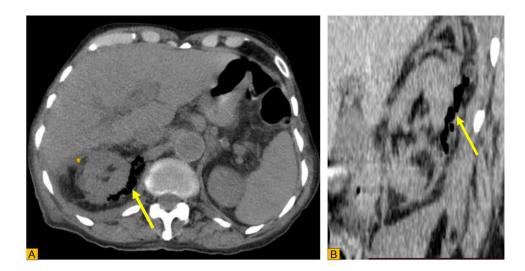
Computed tomography scan in axial (A) and sagittal (B) view: presence of gas locules in the right kidney parenchyma extended to the perinephric space (arrow) with perinephric fat stranding (star).
